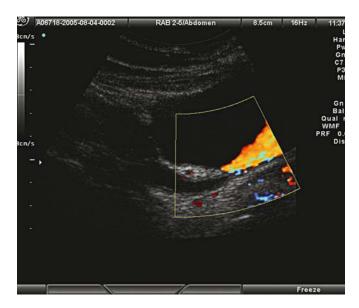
Ultrasound scan done 3 months later shows good efflux from the reimplanted ureter
